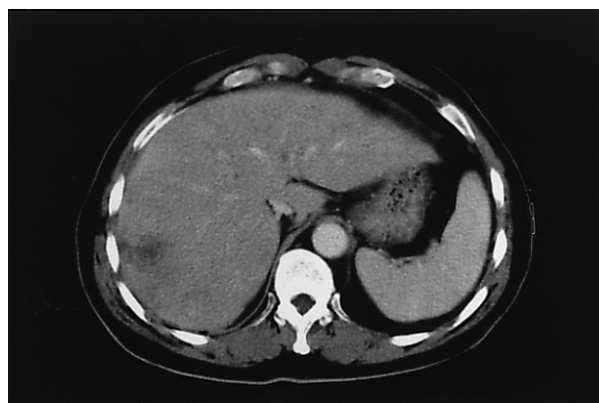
Case 1. CT reveals a tumor in the right lobe of the liver with cirrhosis.
